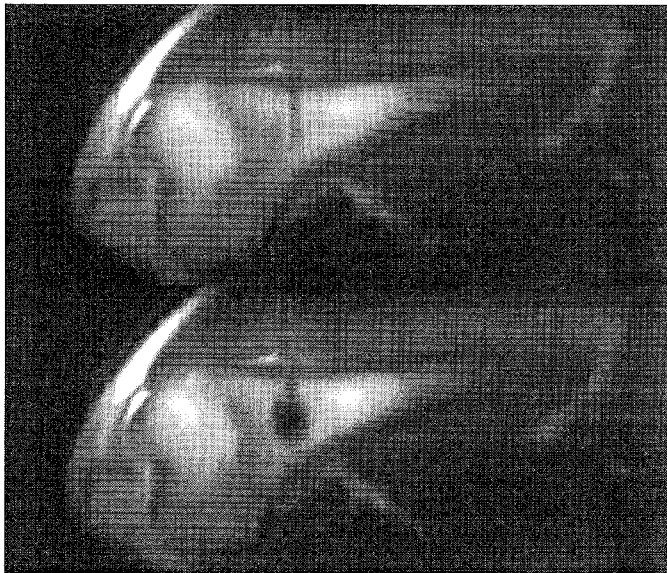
Fig A T2-weighted LoLo sequence. Coronal view of the inactive (above) and active probe (below) within the bone marrow.
